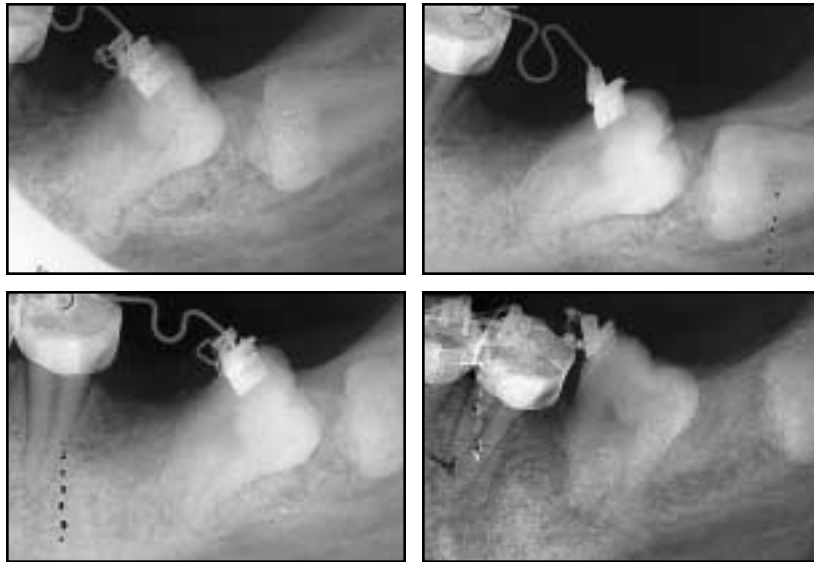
Treatment progress radiographs.
